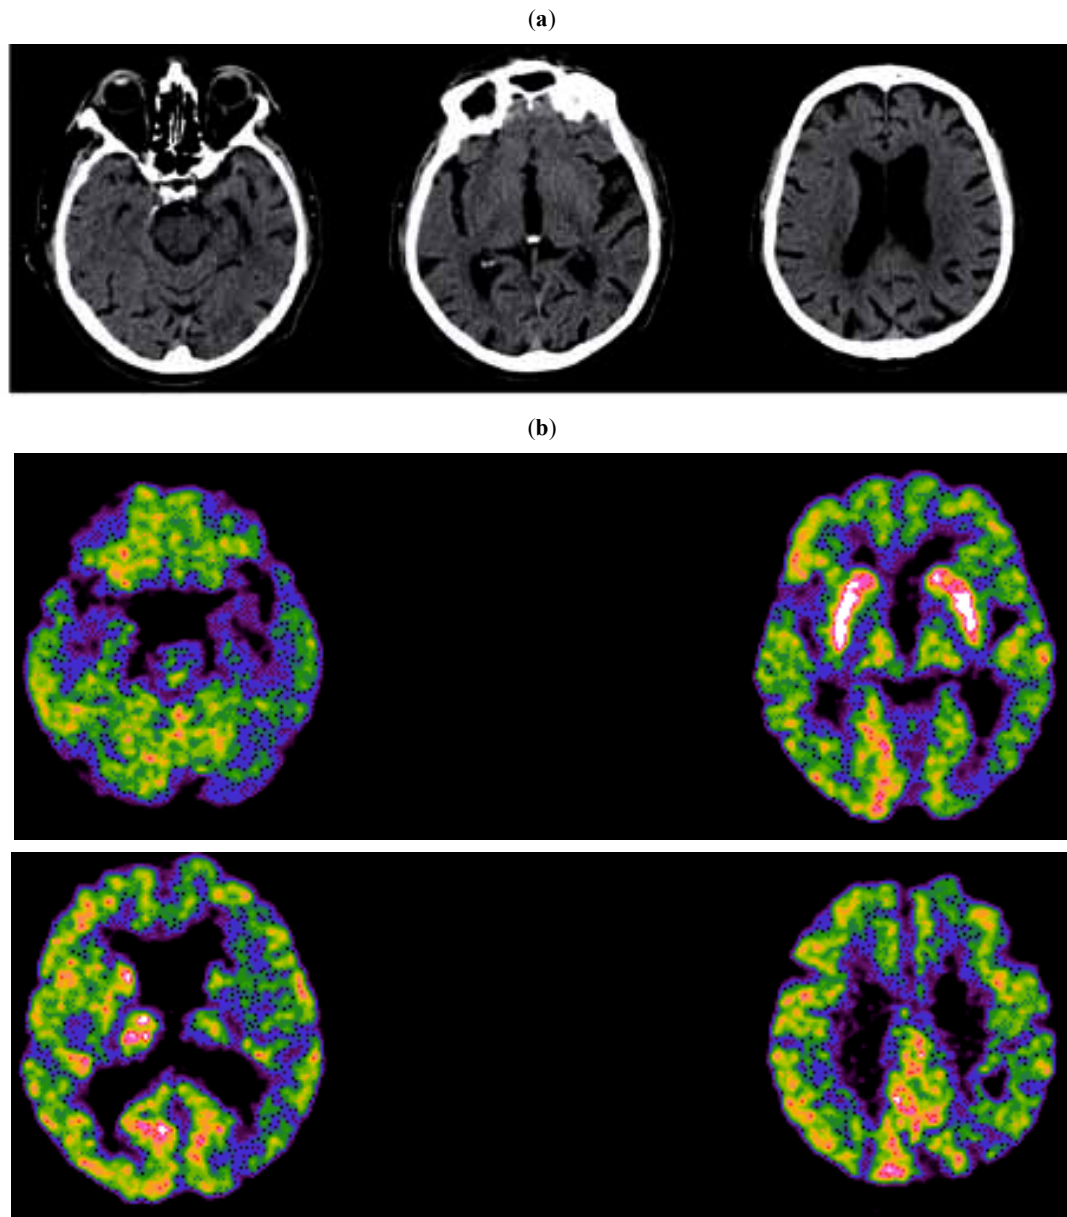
The Computed Tomography (a) and the FDG-PET (b) scans of a 85-year old man with memory deficit and mild impairment in executive functions and visuospatial tasks are reported. The MMSE score was 28 and the everyday functioning was fully preserved, thus qualifying this patient as a multi-domain amnesic MCI on a clinical ground. Neuroimaging disclosed a AD-like pattern, with significant atrophy in left medial temporal lobe, lateral temporal cortex and moderate ventricular enlargement (a), and hypometabolism in several areas of the left hemisphere, notably the posterior parietal cortex, the posterior cingulate and precuneus, and medial temporal lobe (b).
